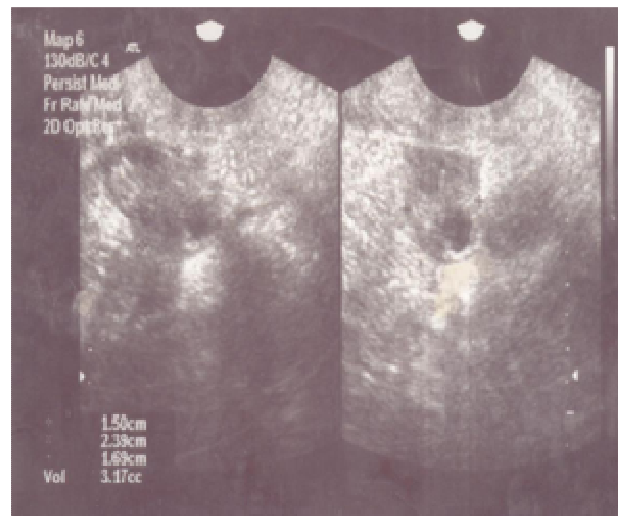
Transvaginal ultrasound image of the ovaries. The cursors define the points of measurements of the ovarian dimensions.
